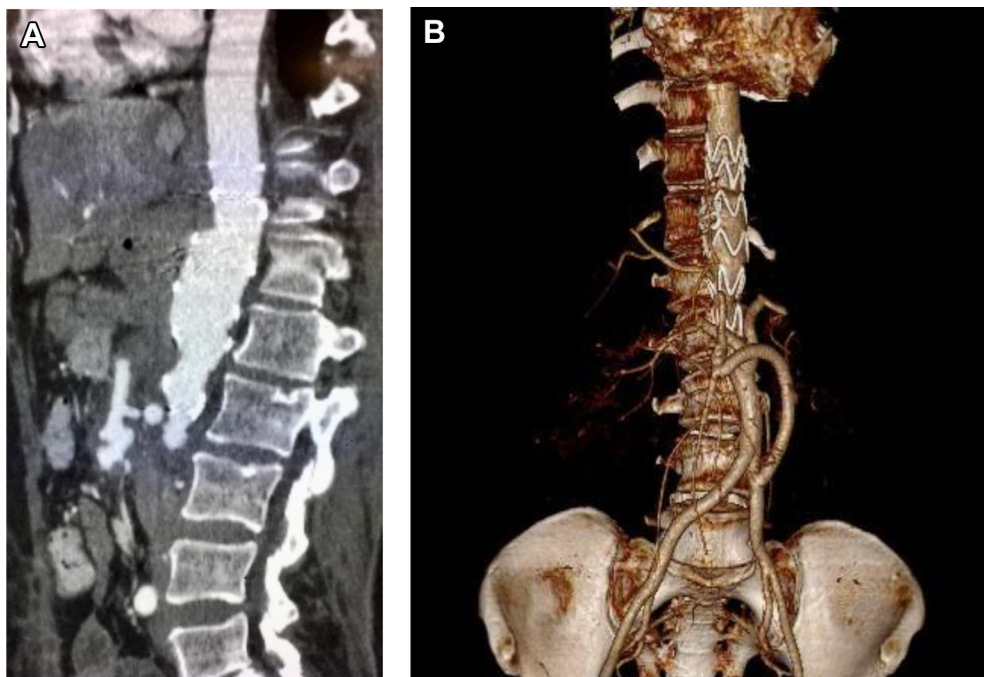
Computed tomography (CT) angiography image after surgery.
